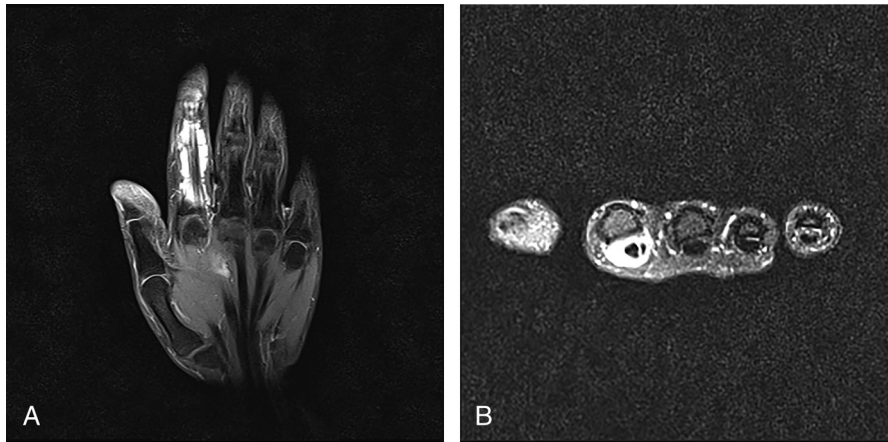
A, B, T2-weighted MR images of the hand in coronal and axial planes shows hyperintense areas of fluid collection around the index finger flexor tendons.
